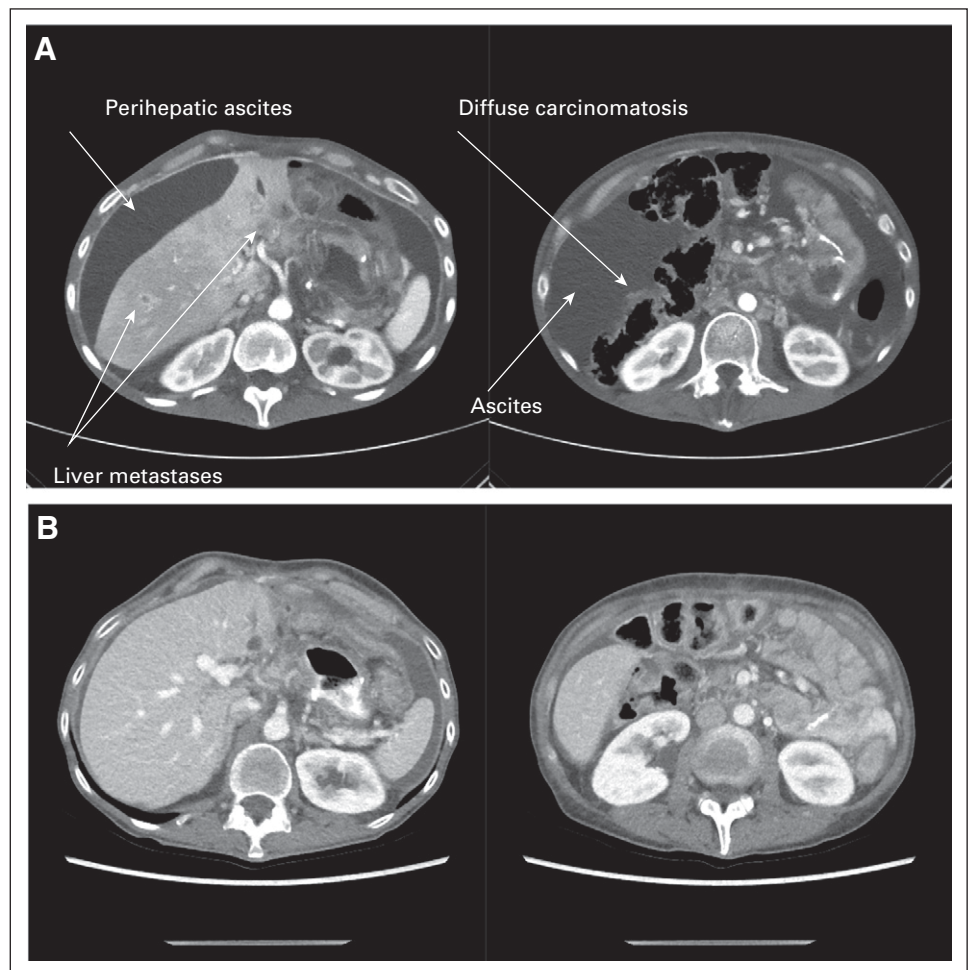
Computed tomography image obtained at baseline on February 20, 2020, before therapy (A) and after four doses of cetuximab plus nivolumab (computed tomography image obtained on April 15, 2020; B), demonstrating complete resolution of carcinomatosis, ascites, and liver lesions.
